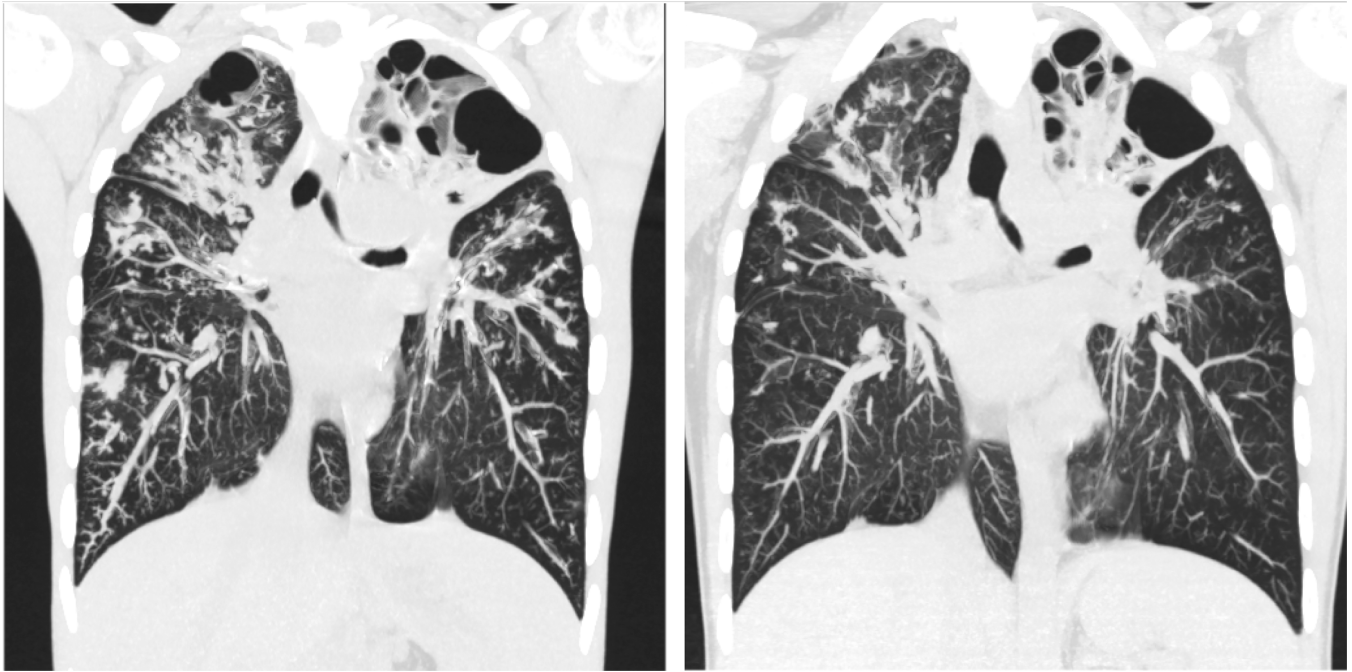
Effect of elexacaftor–tezacaftor–ivacaftor (ETI) on lung disease in a young man homozygous for 508del CFTR mutations. After his first visit to our center in January 2019, he received nine courses of antibiotics and was evaluated for lung transplantation. Since initiating ETI through a compassionate use program in September 2019, he has not had a cystic fibrosis exacerbation, his FEV₁ improved from 26% to 50% predicted, his body mass index improved from 14.5 to 17.6, and he returned to full-time employment. Computed tomographic imaging in October 2019 (right), after 1 month of ETI, demonstrated marked reduction in areas of mucus impaction compared with before (left).
